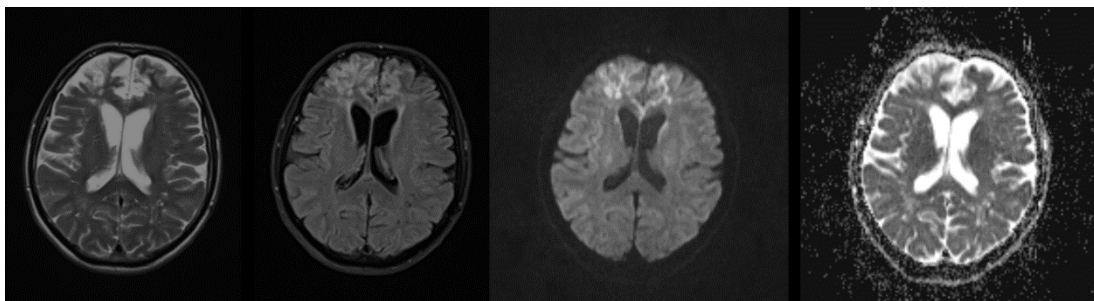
MRI scan of the brain showing cortico-subcortical and parasagittal hypersignal changes, predominantly in the bi-frontal region with more pronounced effects on the right side, accompanied by a slight diffusion restriction.
